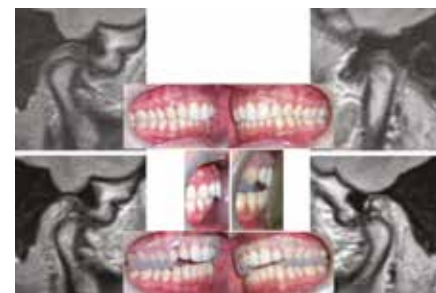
Above: MRI without the Ri.P.A.Ra. bite in the mouth with disc displacement. Below: MRI with the Ri.P.A.Ra. bite in the mouth without disc displacement.
